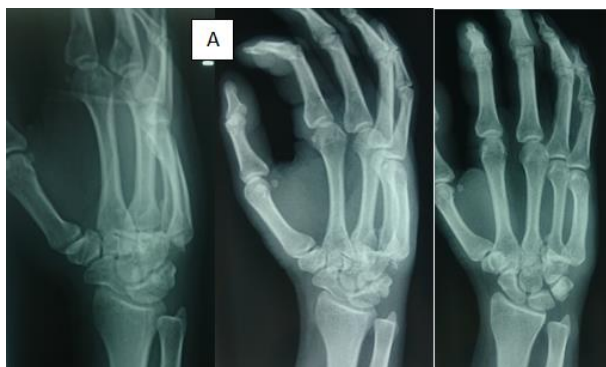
Figure A shows the plain radiographs of the affected right wrist.
